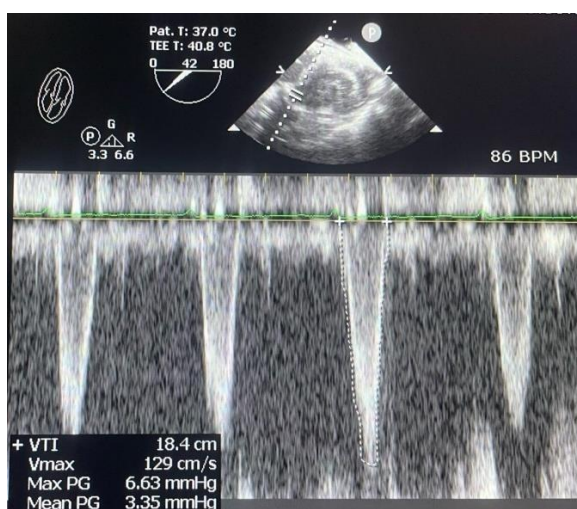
TEE deep transgastric view pulse wave doppler showing reduced gradient across aortic valve post AVR
